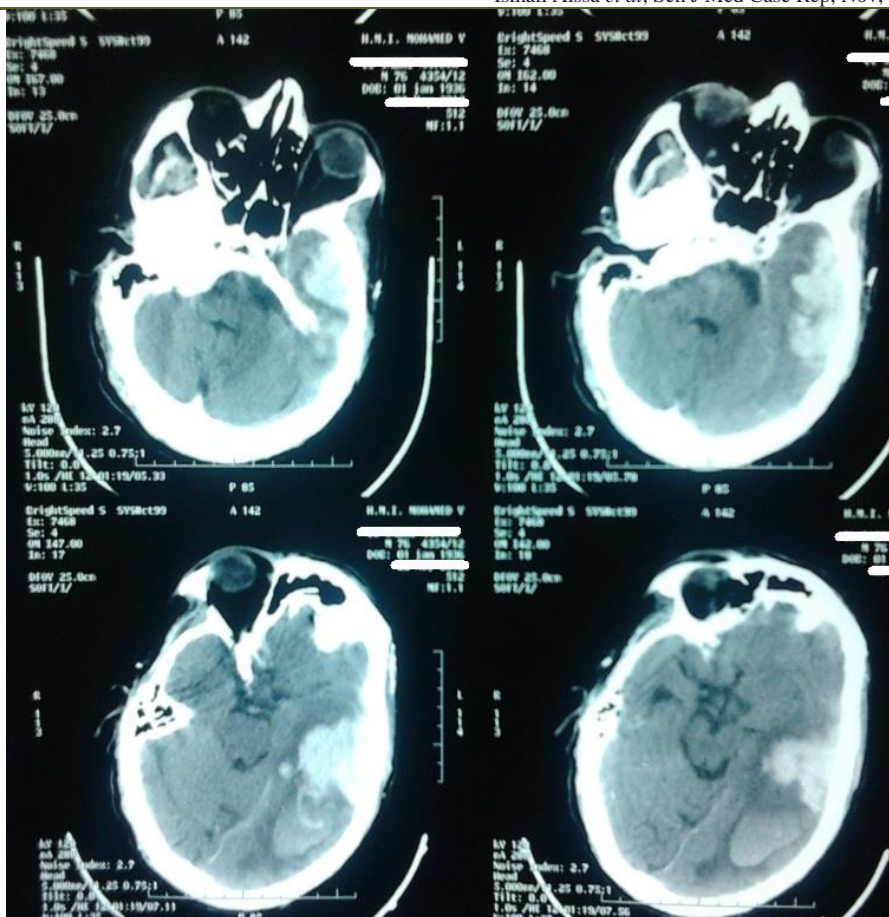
Preoperative axial cranial CT scan showing a left temporoparietal hematoma with a mass effect on the midline
